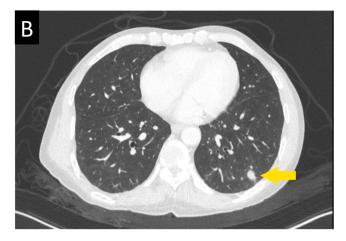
CT scan of the chest showing 7×11 mm nodule (yellow arrow).
